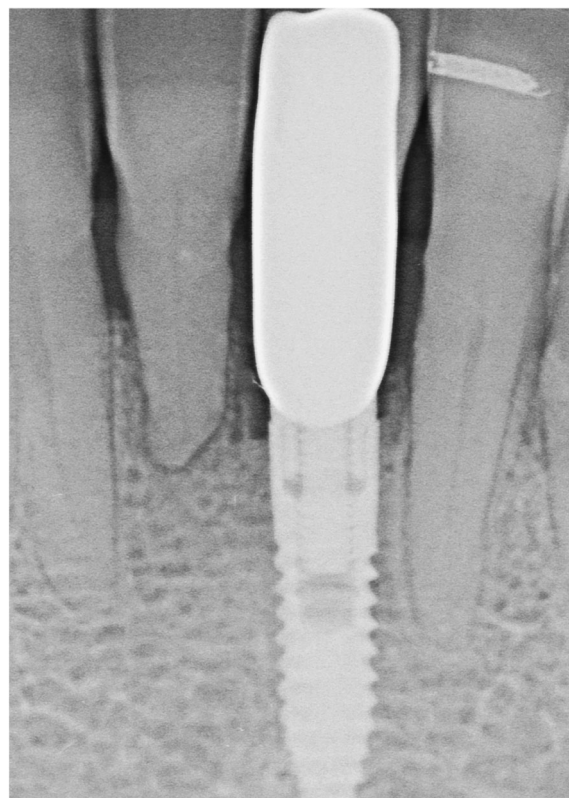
Radiographic view of implant-supported restoration
